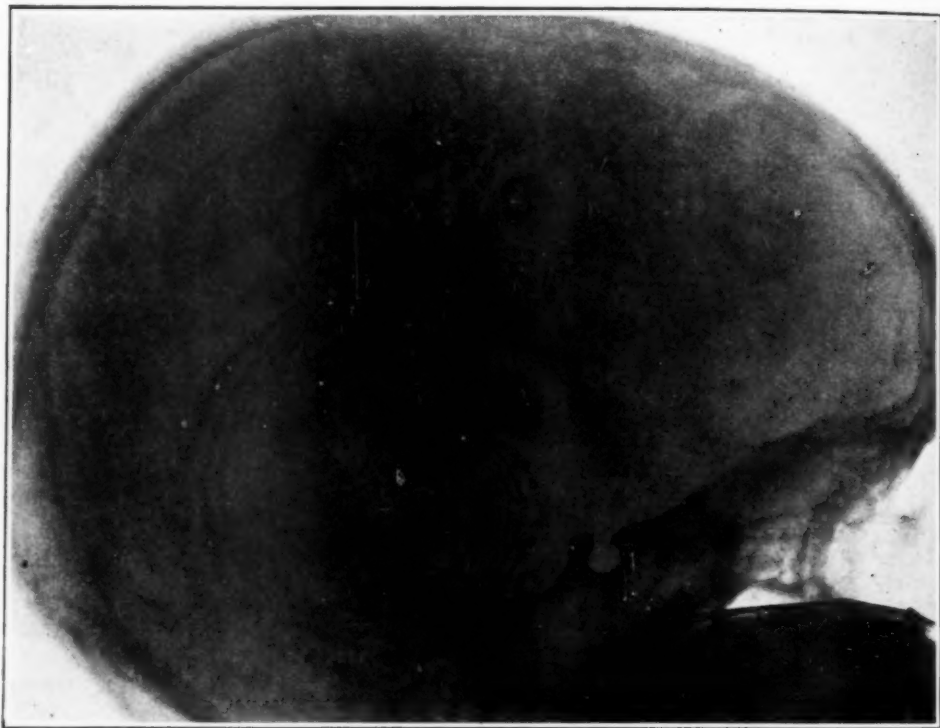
X-ray to show normal sized sella in Case 2.
